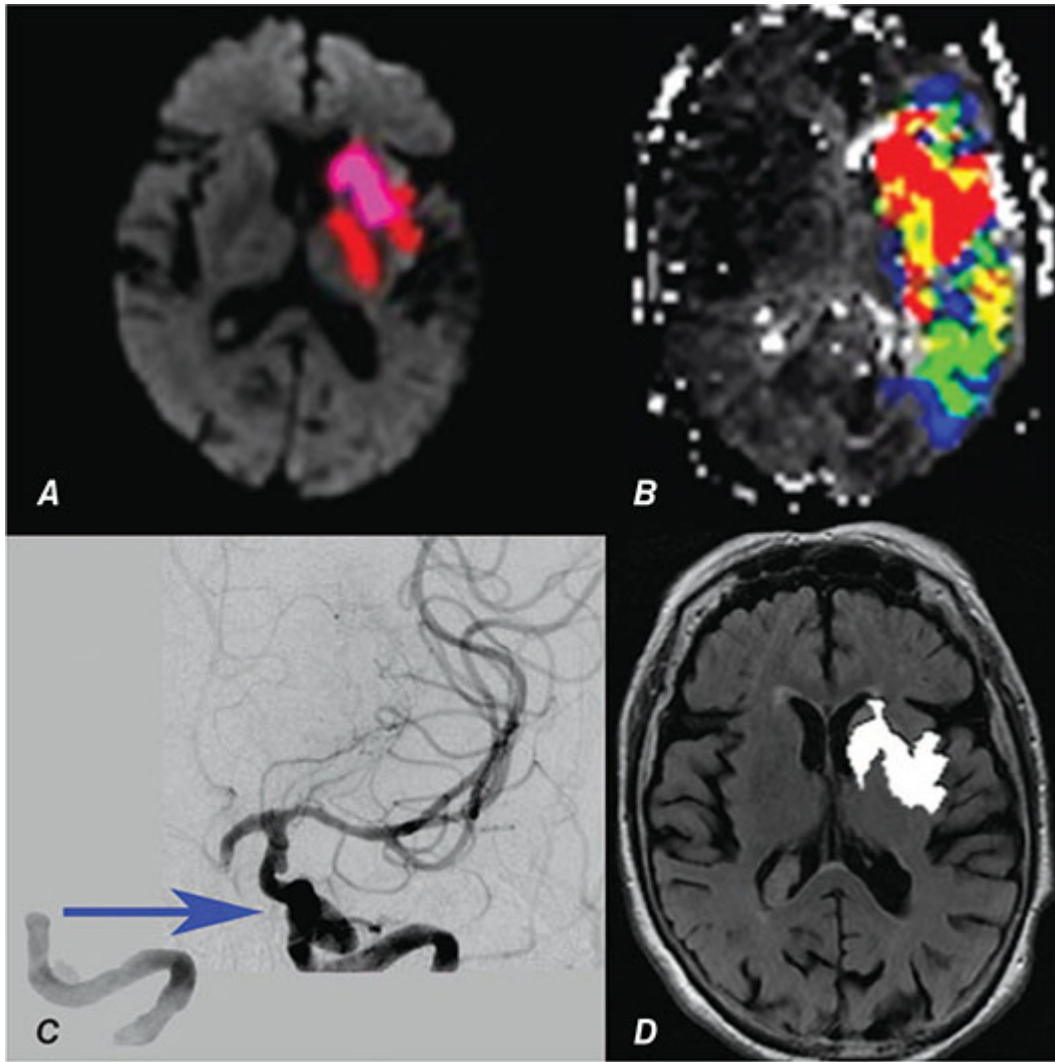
Magnetic resonance imaging (MRI) of acute stroke. A. MRI diffusion-weighted image (DWI) of an 82-year-old woman 2.5 h after onset of right-sided weakness and aphasia reveals restricted diffusion within the left basal ganglia and internal capsule (*colored regions*). B. Perfusion defect within the left hemisphere (*colored signal*) imaged after administration of an IV bolus of gadolinium contrast. The discrepancy between the region of poor perfusion shown in B and the diffusion deficit shown in A is called *diffusion-perfusion mismatch* and provides an estimate of the ischemic penumbra. Without specific therapy, the region of infarction will expand into much or all the perfusion deficit. C. Cerebral angiogram of the left internal carotid artery in this patient before (*left*) and after (*right*) successful endovascular embolectomy. The occlusion is within the carotid terminus. D. Fluid-attenuated inversion recovery image obtained 3 days later showing a region of infarction (*coded as white*) that corresponds to the initial DWI image in A, but not the entire area at risk shown in B, suggesting that successful embolectomy saved a large region of brain tissue from infarction. (*Used with permission from Gregory Albers, MD, Stanford University.*)
